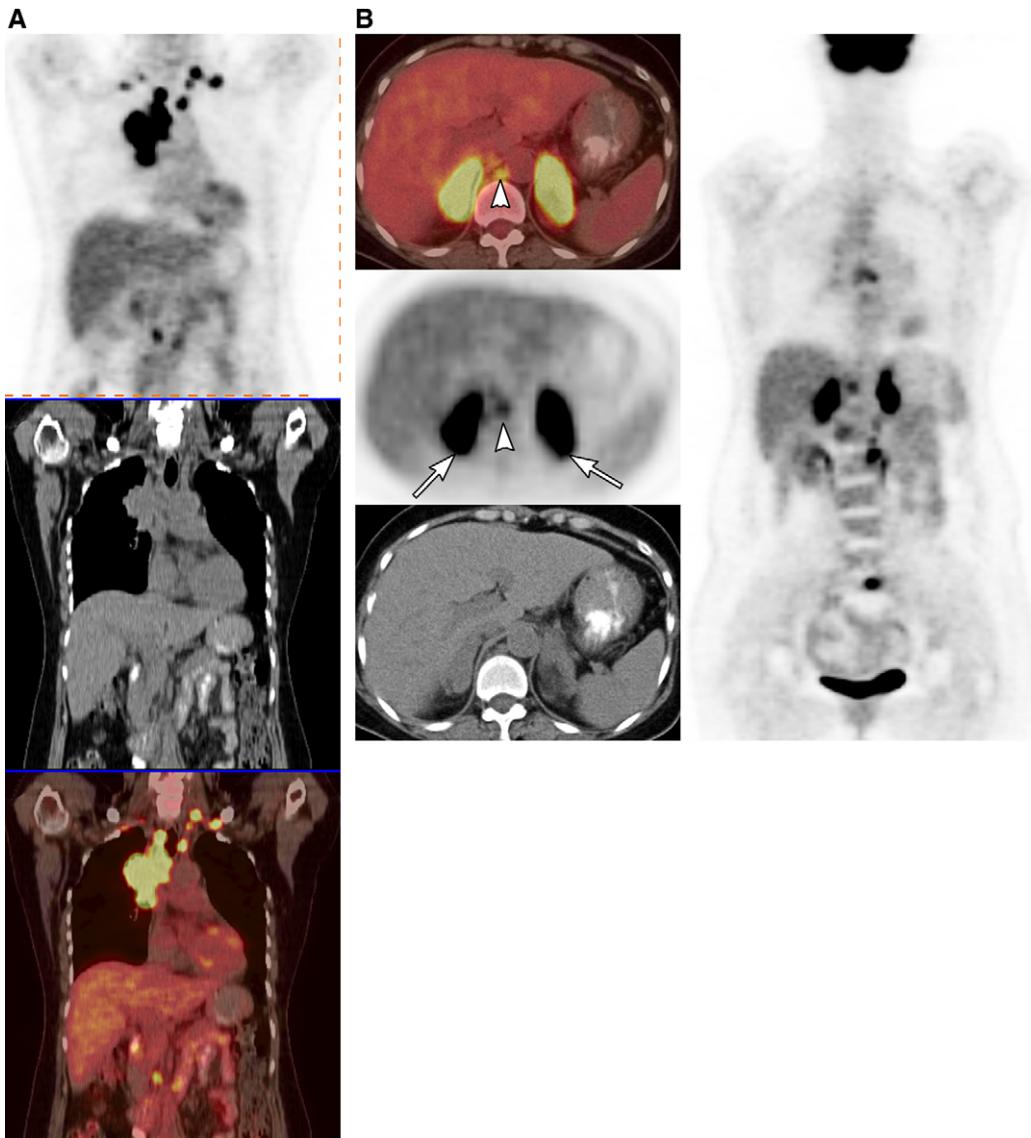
A 56-year-old woman with non-small cell lung carcinoma. (A) FDG-PET scan demonstrates increased uptake in the right upper lung in a paramediastinal mass with lymph node metastases bilaterally in the lower neck, paratracheal region, and the para-aortic region in the upper abdomen. (B) There is also increased activity in the adrenal glands (arrows) and in a retrocrural lymph node (arrowhead) consistent with metastases.
